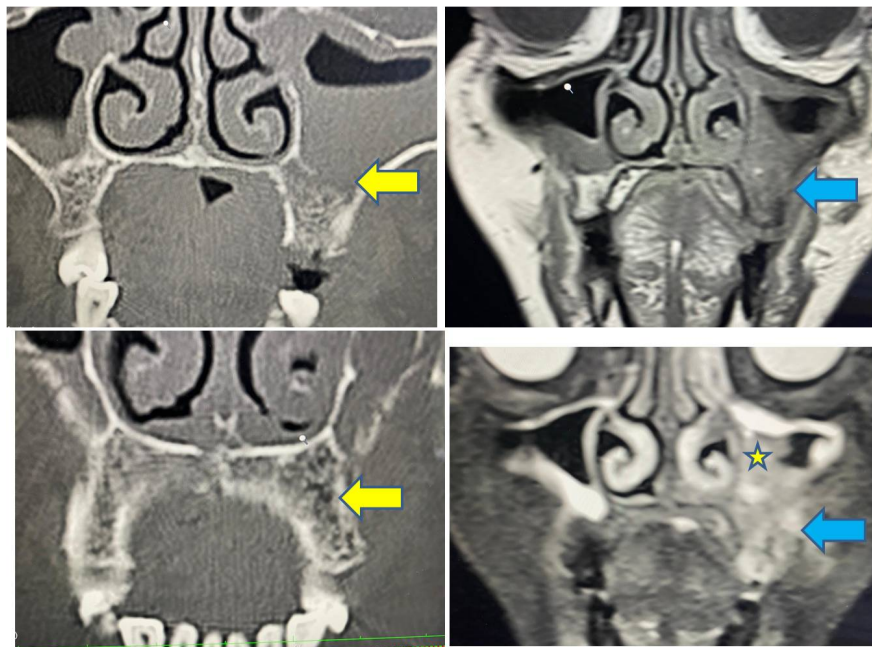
a/b/c/d. Bone infiltration by Mucormycosis. Coronal CT (above/below) shows erosion of floor of left maxillary sinus; there is also rarefaction of rest of alveolar bone but actual infiltration is rather difficult to appreciate; Coronal T1/T2FS (above and below) MRI shows complete replacement of marrow fat at left maxillary alveolar bone compared to right side. T2W images show infiltrative tissue; bone marrow infiltrative changes are easily appreciated on MRI. Note the T2 low signal changes within the left maxillary mucosal disease (yellow star) shows erosion of left and intraconal (blue arrow) compartments.
